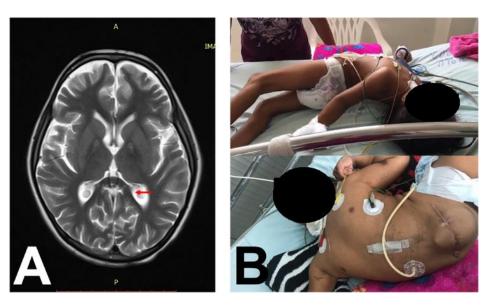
A. Brain MRI of the patient showing the classic "tiger's eye" pattern at the level of the globus pallidus secondary to iron deposits in a PKAN. B. Refractory ED after the patient was taken to surgery for implantation of a pump for intrathecal infusion of baclofen despite having reached a dose of 600 micrograms per day.
